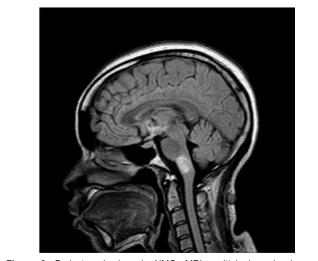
Brainstem Lesions in NMO. MRI sagittal view showing nonenhancing hyperintense lesions of the upper medulla and lower pons.
